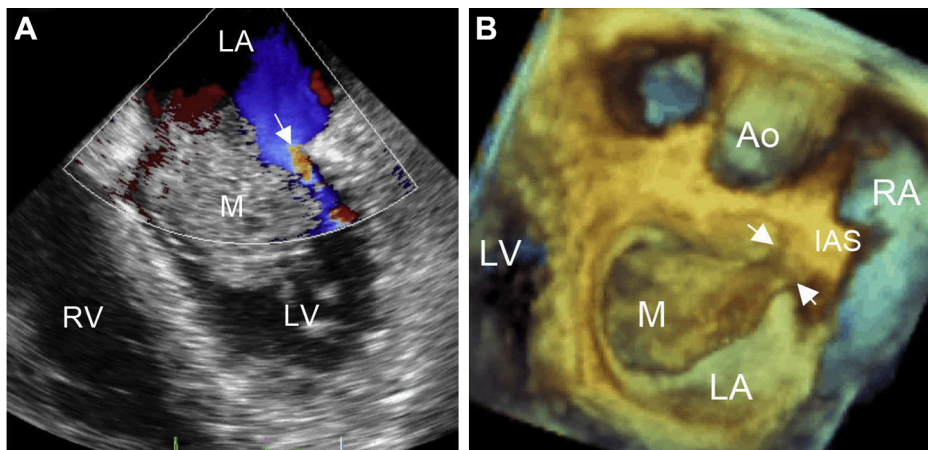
(A) A case of left atrial myxoma (M) with obstruction of the left ventricle inflow and minimization of the flow (arrow) toward the left ventricle; (B) enface left atrium view of real-time three-dimensional transesophageal echocardiography (TEE) shows a pedicle of the myxoma (arrow) attached to interatrial septum and protruding through the mitral valve. Ao = aorta; IAS = interatrial septum; LA = left atrium; LV = left ventricle; RA = right atrium; RV = right ventricle.
